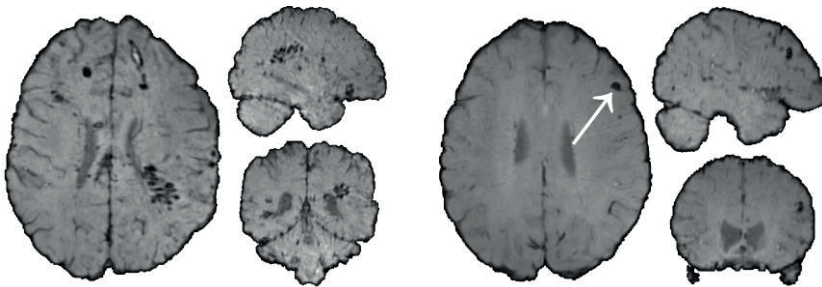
Two examples of susceptibility weighted MR images taken from TBI patients. The black dots seen in the images (arrow in the right subject image) are signal voids caused by TBI induced microbleeds.
